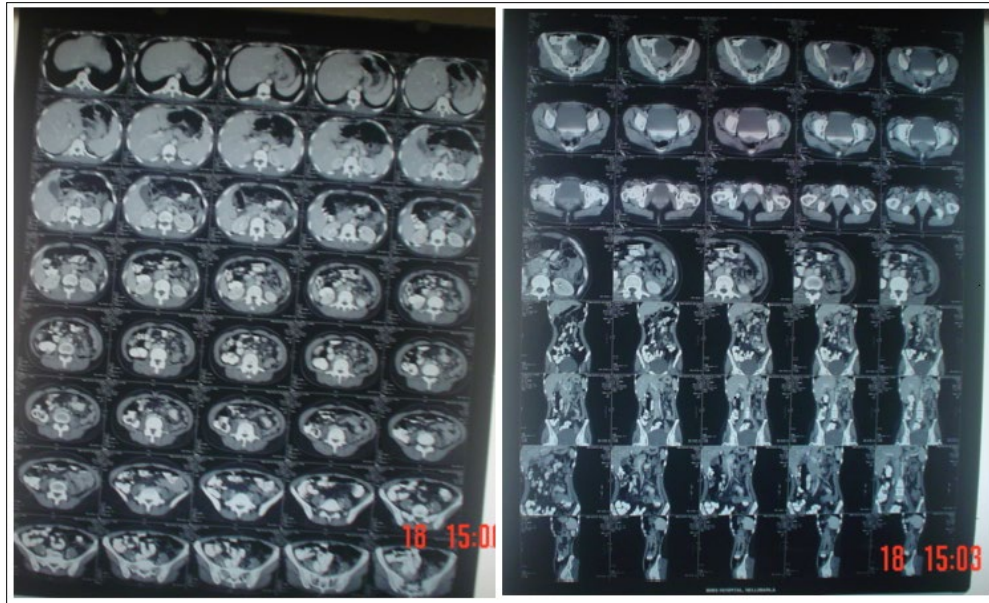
Showing the CT scan findings of the mesenteric cyst.
